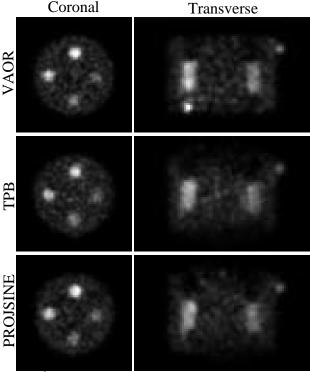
20<sup>th</sup> iteration, Gaussian smoothed post-reconstruction, 3 summed reconstructed slices of the cylinder and syringes in the (LEFT) coronal and (RIGHT) transverse planes. Images are SPECT-based attenuation corrected collected with the indicated trajectories.
